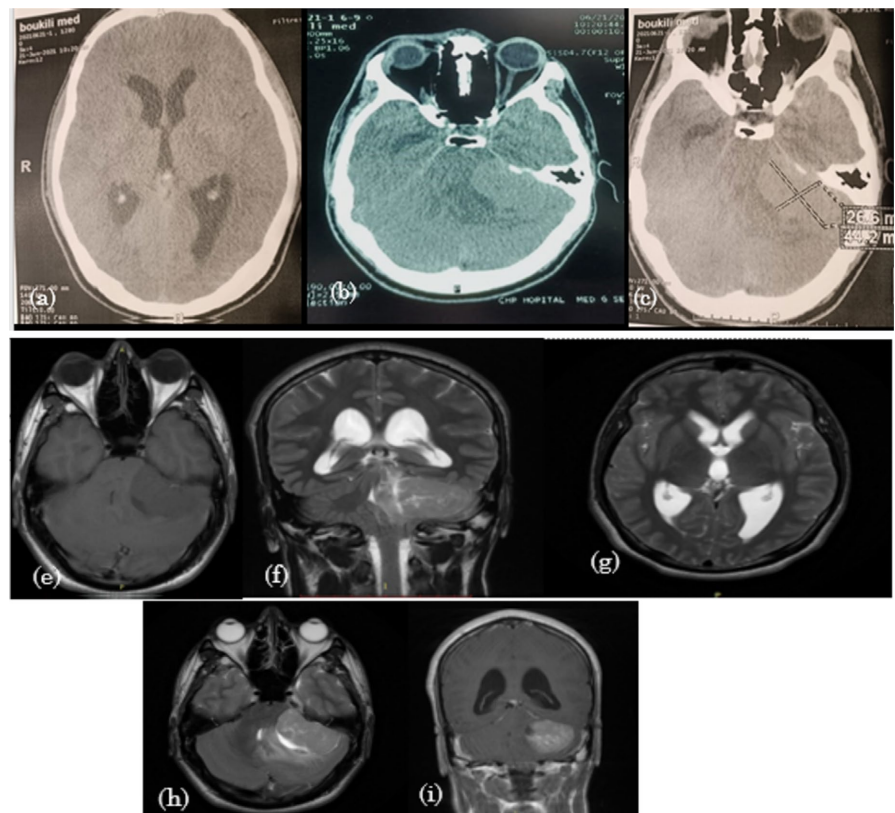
Pre-operative brain CT scan (a)-(c) showing an extra-axial mass at the left pontocerebellar angle compressing the fourth ventricle and causing tri-ventricular hydrocephalus. Pre-operative brain MRI: (e) Axial T1 showing a hypointense mass and (f) Coronal T2 showing a heterogeneous mass in the left cerebellopontine angle. (g) Axial T2 showing tri-ventricular hydrocephalus. (h) Axial T2 FLAIR showing adjacent cerebellar edema. (i) Coronal T1 after contrast injection showing moderate heterogeneous enhancement and a large tentorial attachment.
